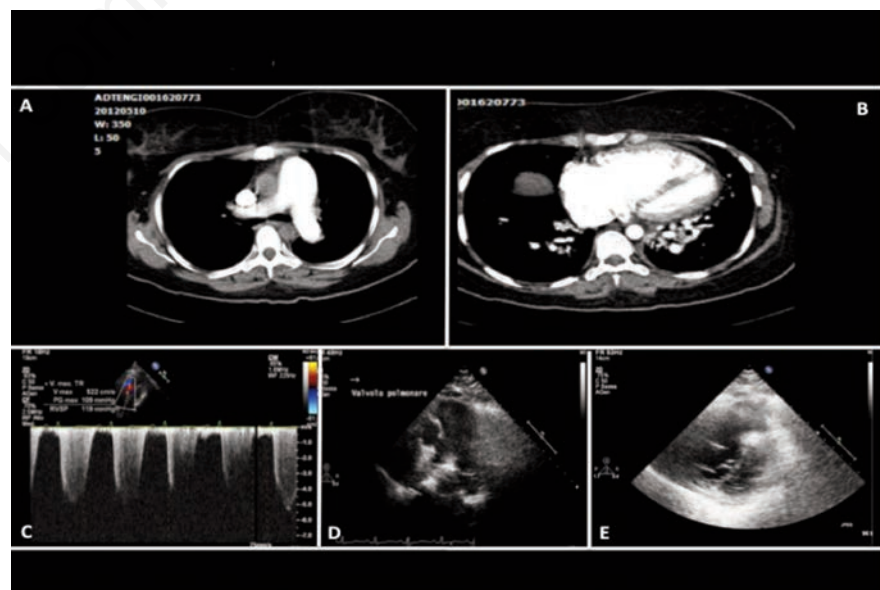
Cardiac imaging. A) and B) Computed tomography scans demonstrating severe idiopathic pulmonary arterial hypertension. Note the markedly enlarged pulmonary artery trunk with tiny branching smaller vessels. C) A transthoracic echocardiogram revealed a right ventricular systolic pressure of 96 mm/Hg. D) A pulmonary artery trunk measuring up to 38 mm was detected. E) Dilatation of right chambers: right atrium was 57 mm in diameter; right ventricle wall measurement was 10 mm.
